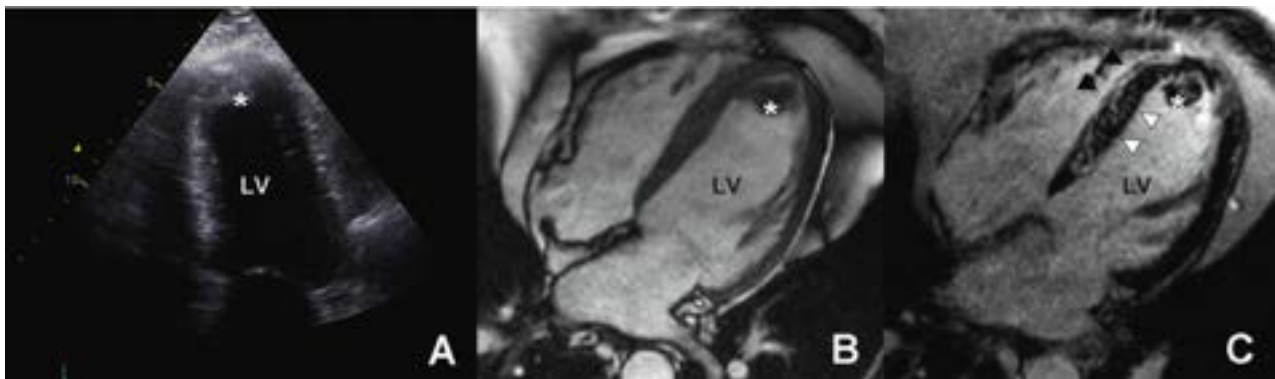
Showing LVT formation on both transthoracic echocardiography and delayed contrast cardiac MRI. A is showing a transthoracic echocardiogram image of an LVT in the apex. B is showing the LVT on late gadolinium enhancement imaging.
